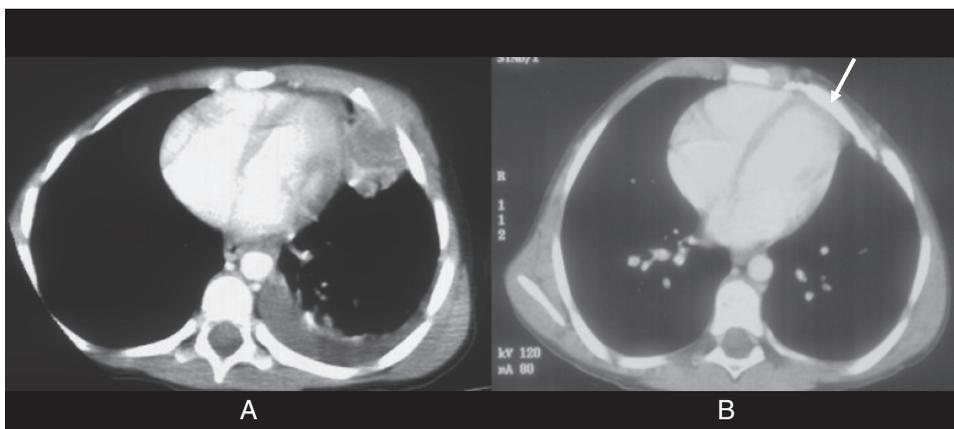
(A) CT scan showing an anterior chest wall PNET that abutted the diaphragm and pericardium. Resection and rigid reconstruction using a mesh-cement sandwich was done after neoadjuvant chemotherapy at 5 years of age. (B) The status of the reconstruction 3 years later. The arrow points to the chest wall prosthesis.
